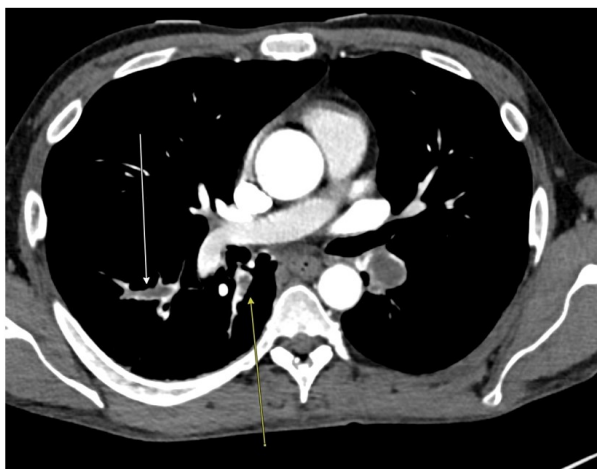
Bilateral lower lobe pulmonary emboli seen on the initial CT scan Abdomen/Pelvis.
